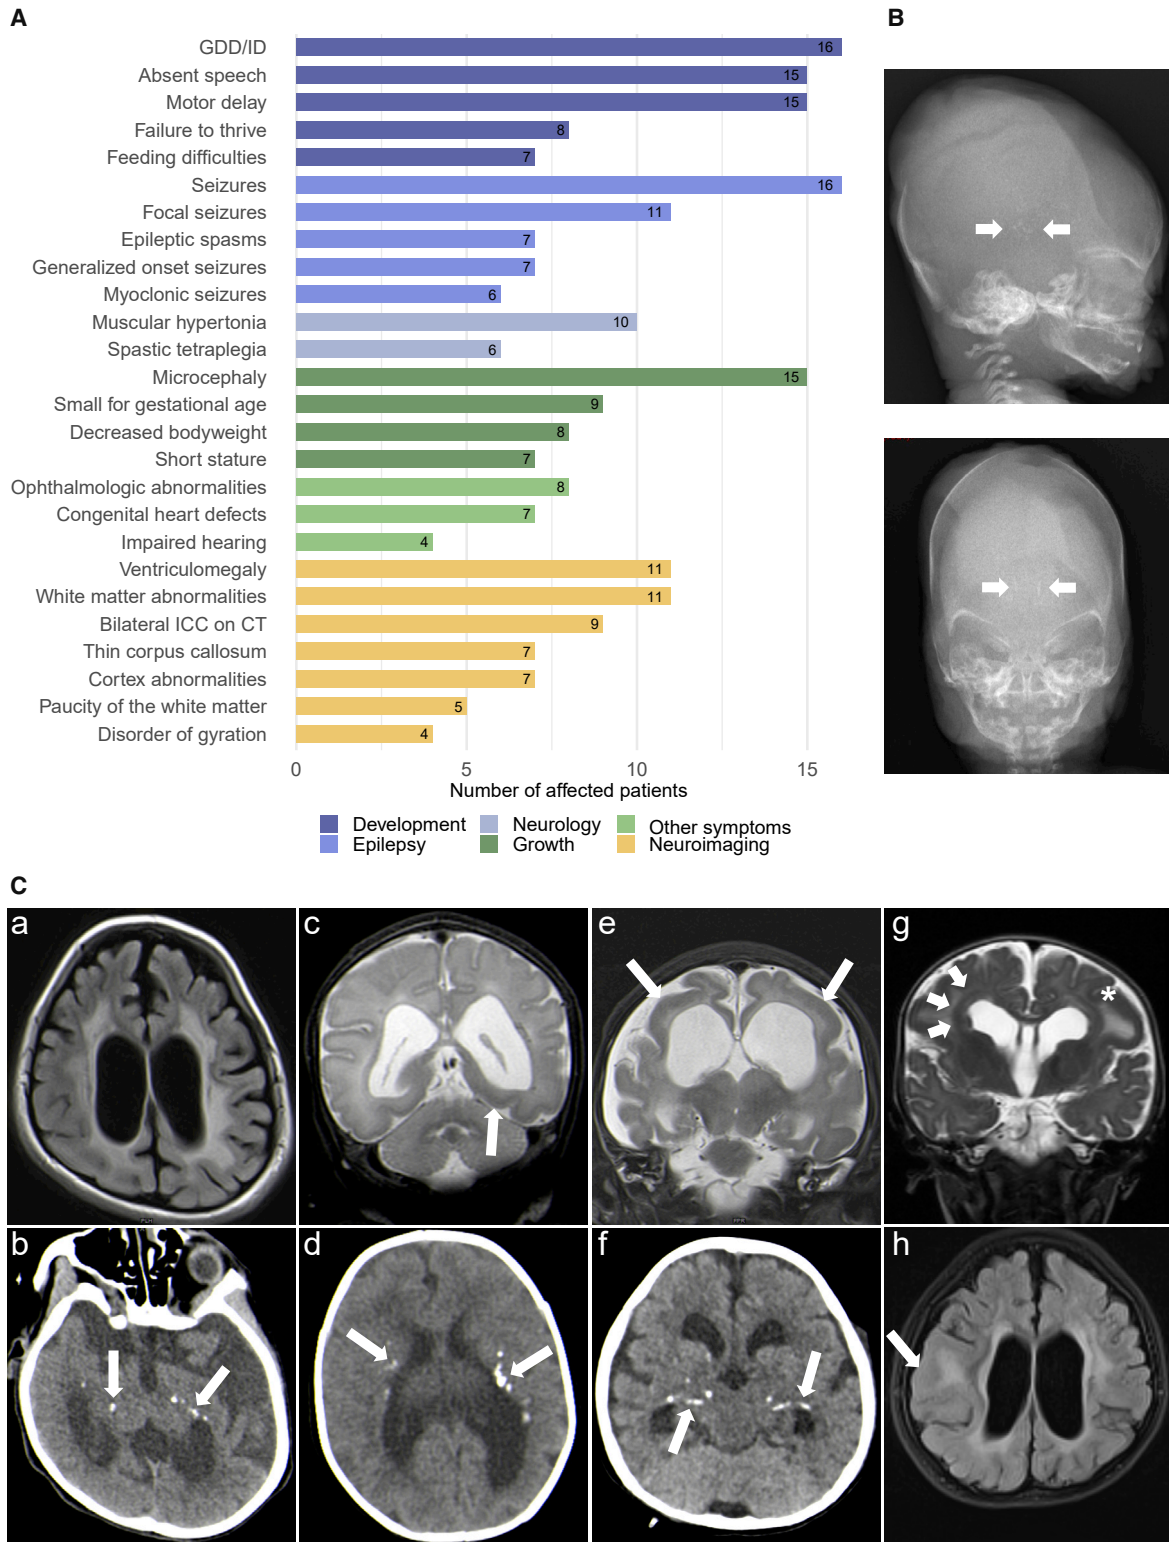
Prevalence of clinical findings, neuroimaging features, and X-ray of the fetus
